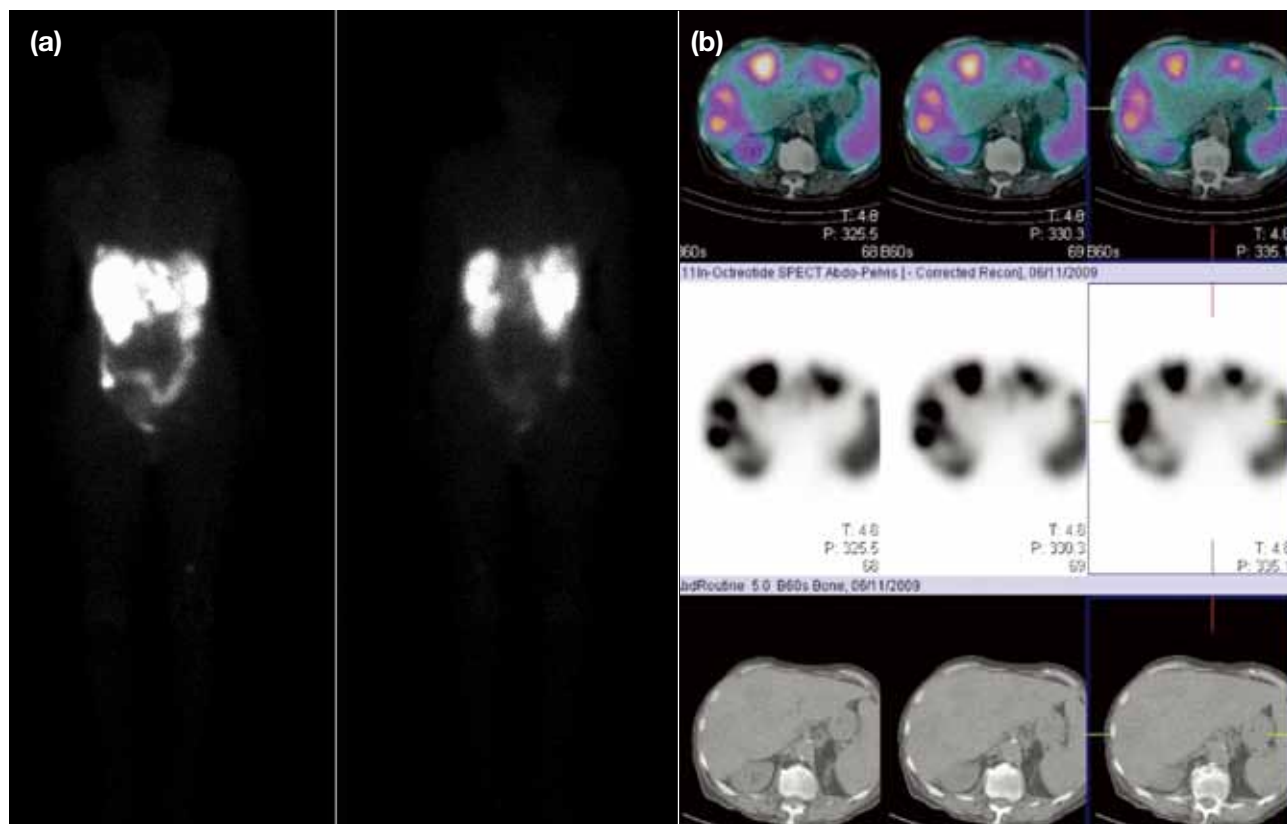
(a) A patient with a large-volume metastatic neuroendocrine tumour in the liver with unknown primary whole-body ^{111}In -pentetreotide images. (b) The site and distribution of the liver metastases are more clearly demonstrated by the single-photon emission computed tomography-computed tomography (SPECT-CT) [note: fused images in the top row, ^{111}In -pentetreotide images in middle row and CT images bottom row].
